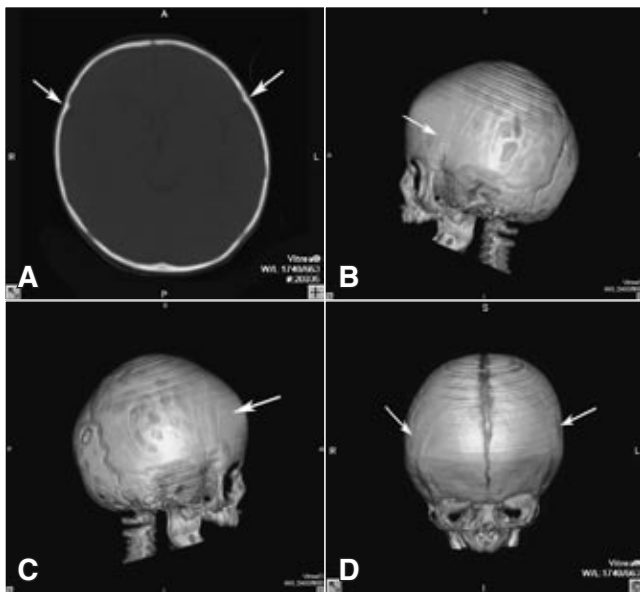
Patient with bilateral coronal synostosis: 2D-CT axial slice shows a closed bilateral coronal suture (arrows) (A); 3D-CT: left lateral view (B), right lateral view (C) and frontal view (D) (arrows) demonstrate the premature closure of the bilateral coronal suture.
